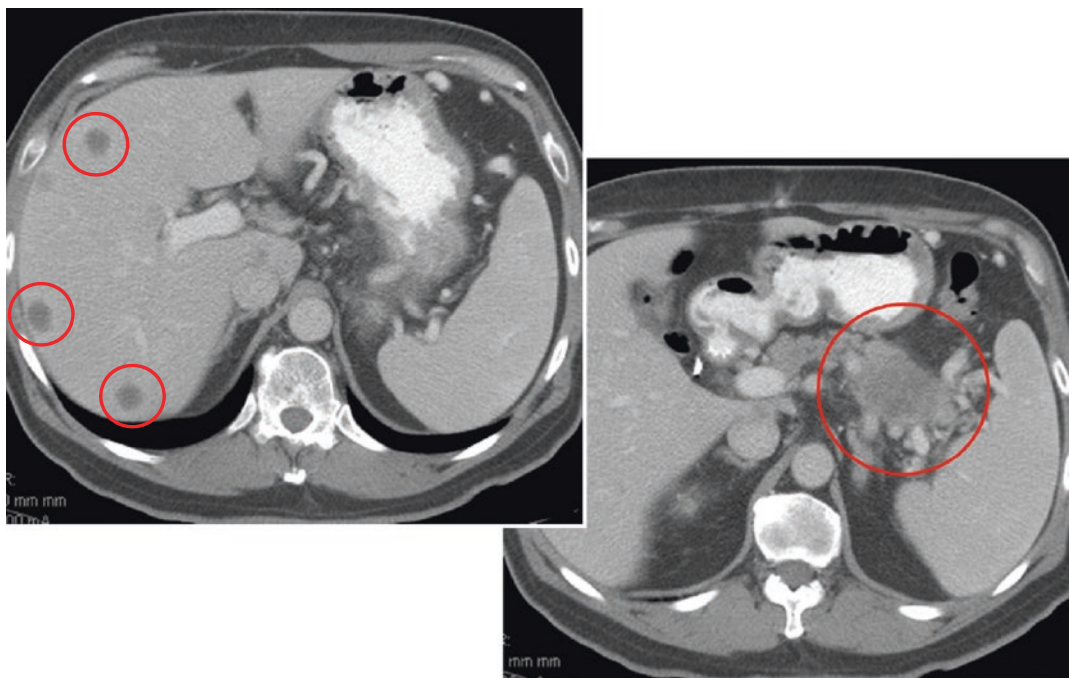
Metastatic pancreatic cancer. Left: CT image of hypodense liver lesions consistent with metastatic spread (circled). Right: CT image of tumor arising from tail of pancreas (circled). Patients with tumors of the pancreatic tail often present with metastatic disease
